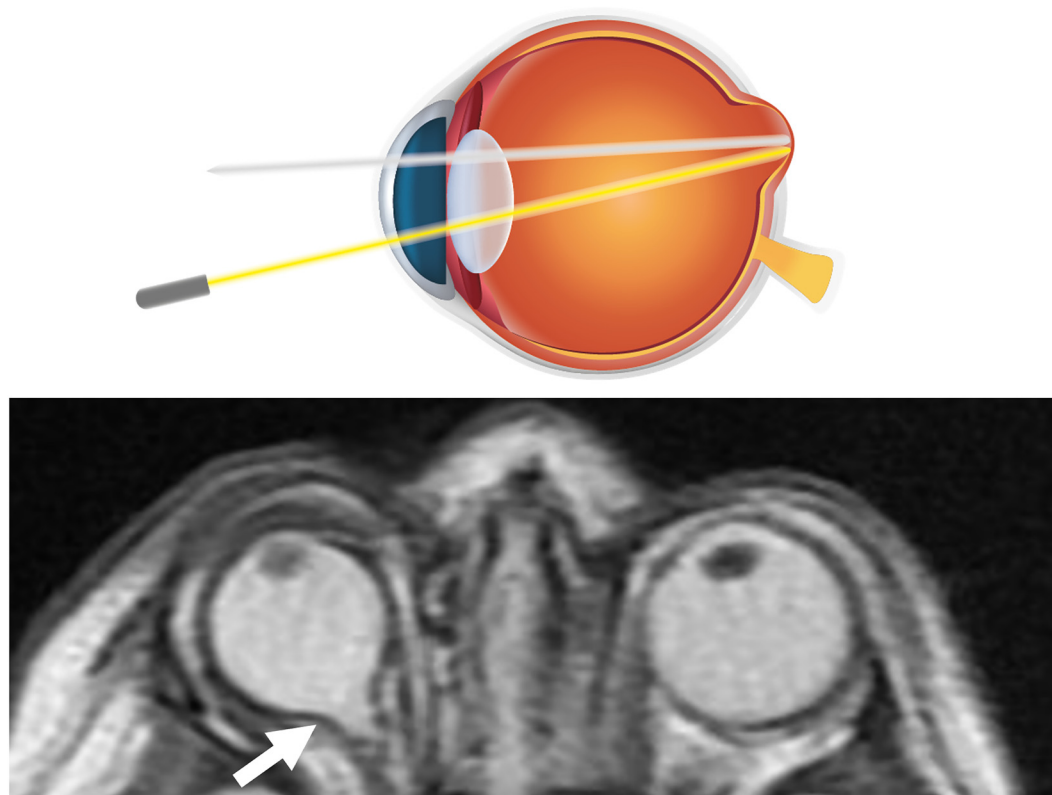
Coloboma. Axial T2-weighted sequence from orbital MR imaging shows microphthalmia of the right eye associated with a coloboma that involves the optic disc (*arrow*).
